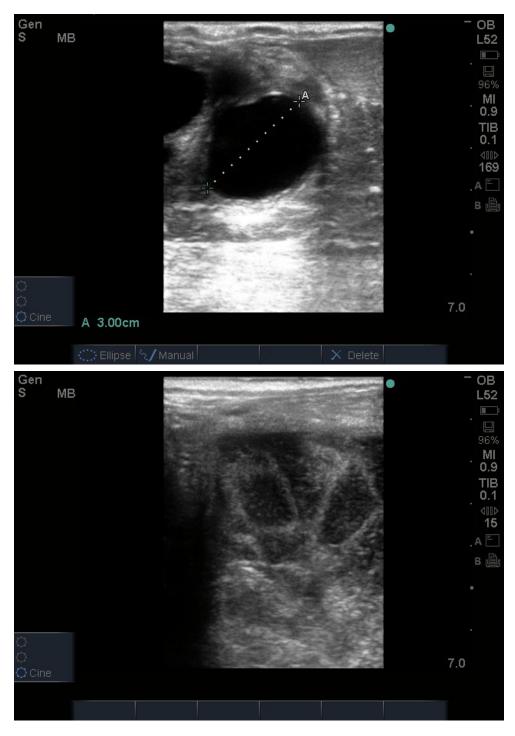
Top - Ultrasound image of an ovary 16 days after ovulation with a dominant follicle. Bottom - An ultrasound image from the same mare demonstrating her uterus with edema of the endometrial folds. Tic marks on the right side of the images equal 10 mm.
